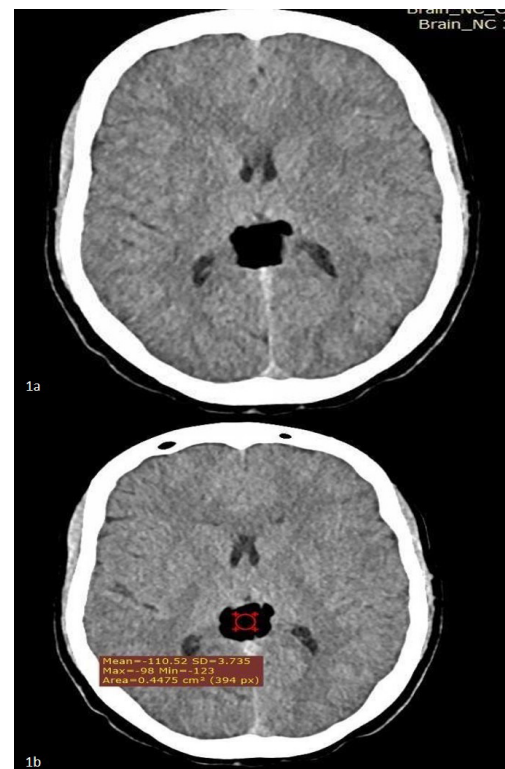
Axial non-contrast CT scan of the brain showing well defined fat attenuating lesion around posterior pericallosal region (Finger 1 and 2). It has lobulated surface.
